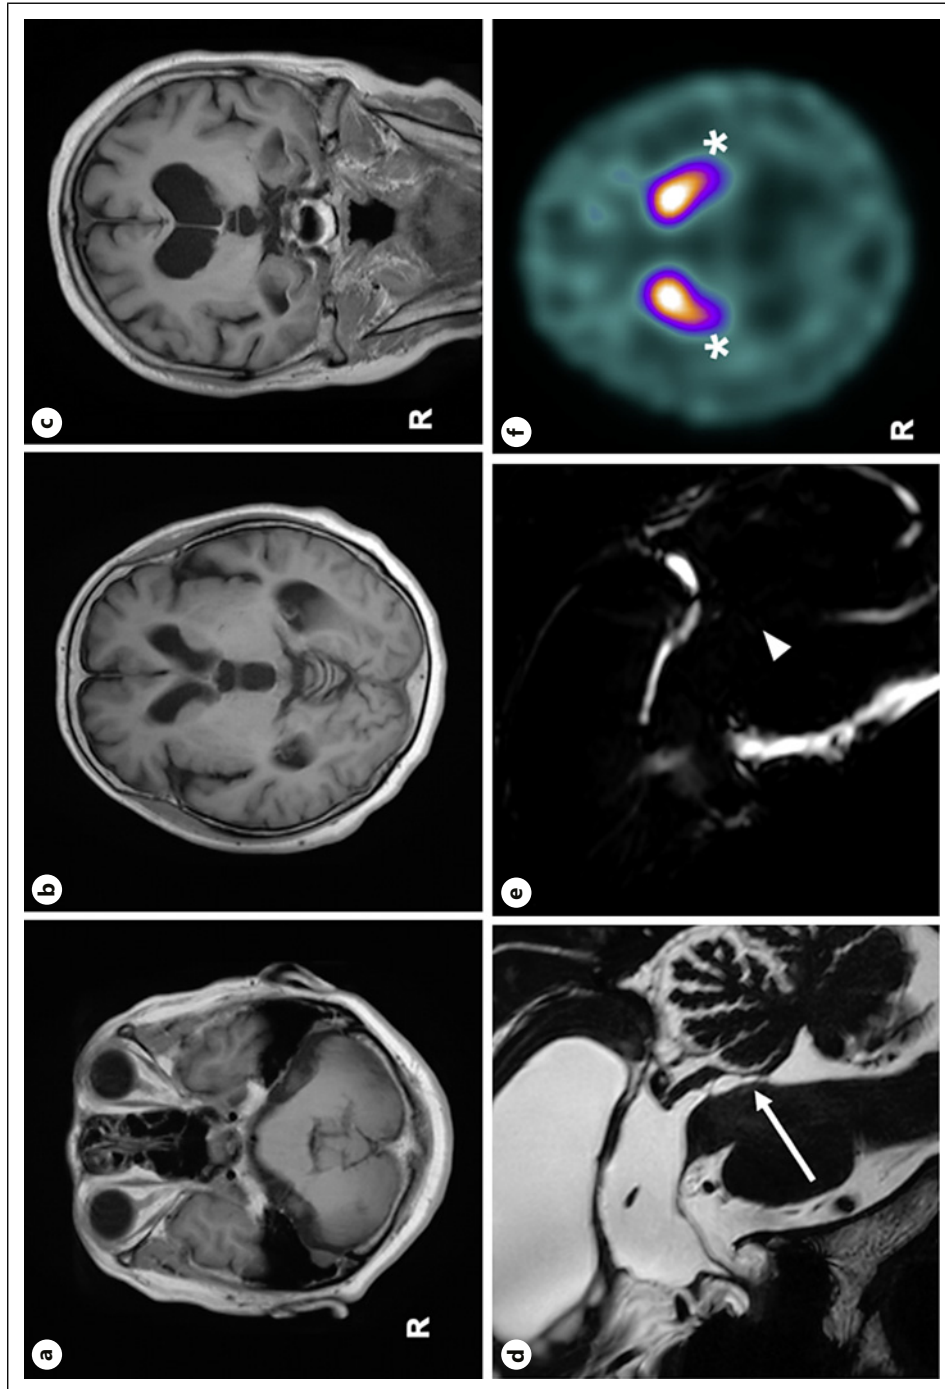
T1-weighted cranial MRI. a, b The axial images of MRI show an enlarged third and lateral ventricle with normal size of fourth ventricle. No evidence of atypical or secondary parkinsonism. c Coronal T1-weighted imaging does not have a feature of DESH. d CISS imaging demonstrates the stenosis of the midbrain aqueduct (white arrowhead). e Phase-contrast cine MRI shows no cerebrospinal fluid flow in the same area (white arrow). f ^{123}I -ioflupane single-photon emission computed tomography (DAT scan™) shows slightly reduced uptake in the bilateral, dorsal parts of the striatum (white asterisk).
